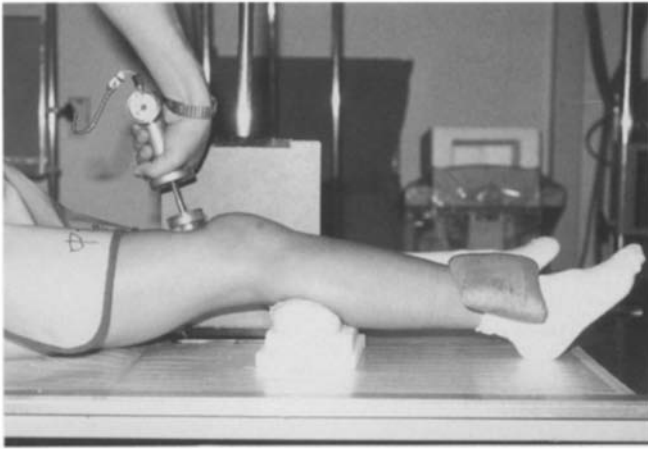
Stress radiography for the diagnosis of ACL deficiency with the knee flexed at 20°
